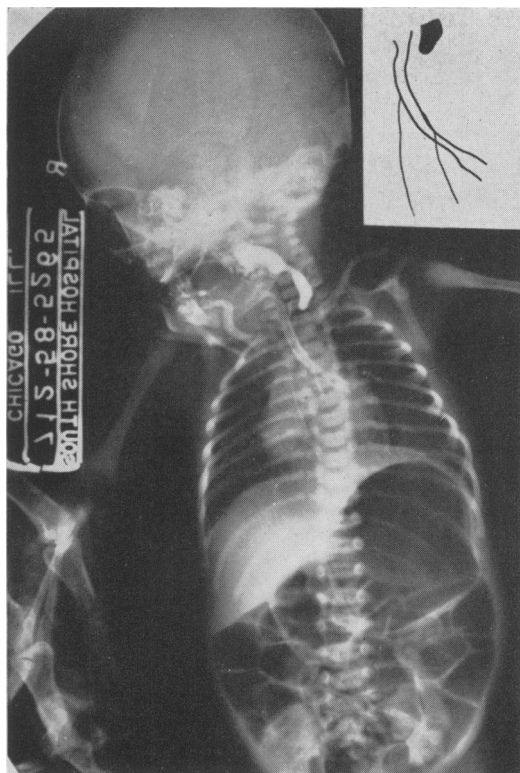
A roentgenogram showing Lipiodol® in the proximal esophageal pouch. Some has "spilled over" into the trachea outlining the left main bronchus. Two fine lines faintly outline the distal esophageal pouch. The insert shows a tracing of these shadows.
